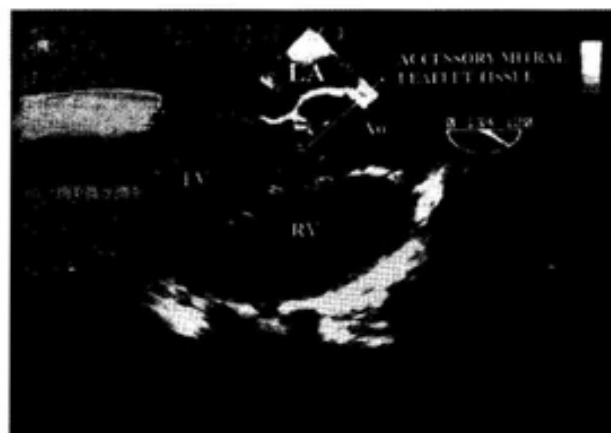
Accessory valve tissue attached to anterior mitral leaflet in two dimensional echocardiography.
